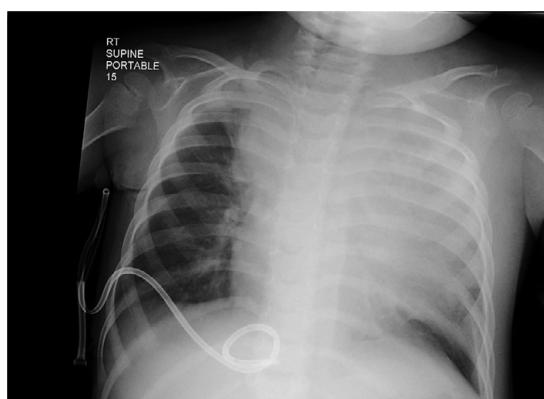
Chest X-ray of child with non-Hodgkin's lymphoma associated with a large anterior mediastinal mass.
